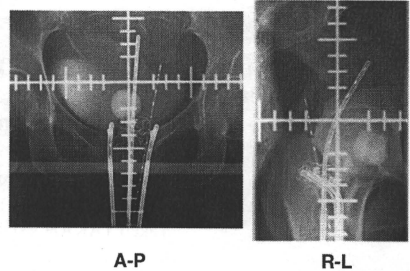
X-ray photographs of needle placement after implantation of a tandem and ovoids.
